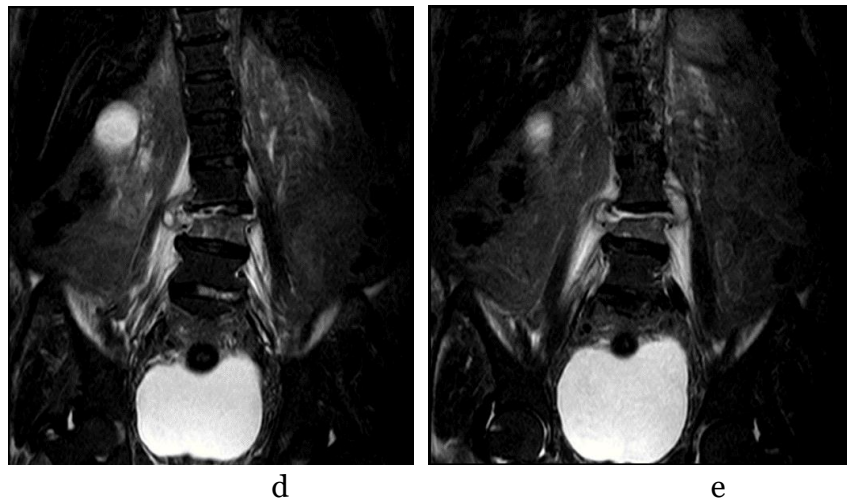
Classic findings of tuberculous spondylitis. (a,b,c,d). T2-weighted, STIR weighted showed L4 vertebral destruction and lesion at the intervertebral L3-L4 disc. (e). STIR weighted shows paravertebral and bilateral musculus psoas abscess.
